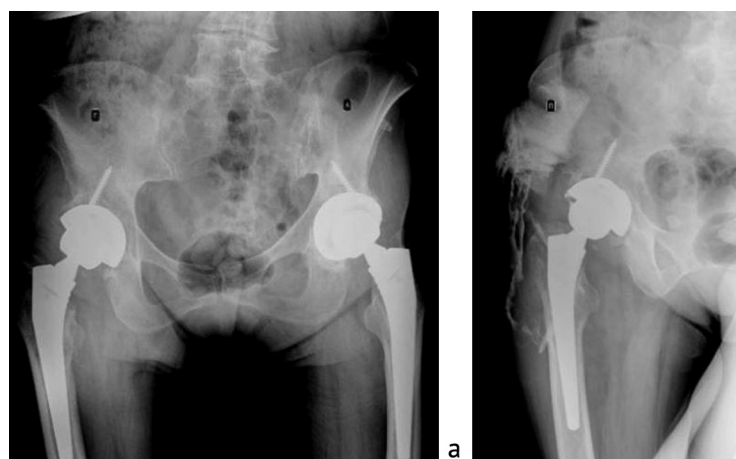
X-rays of the pelvis upon admission to the federal medical center: a X-ray of the pelvis; b fistulography of the right hip joint, the spread of a contrast agent into the joint cavity
